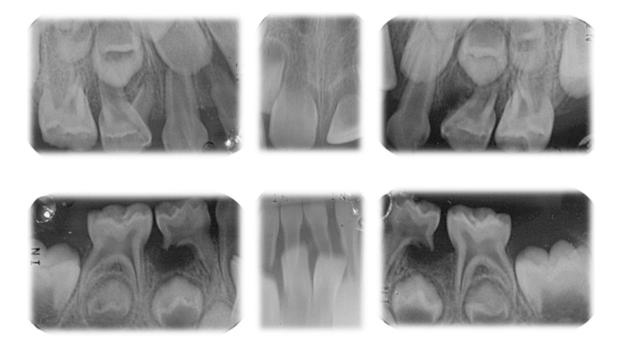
The periapical radiographs showed a primary dentition with broader pulp cavity and irregular circumpulpar dentine, high pulp horns, radicular resorptions and radiolucent images compatible with periapical lesions
